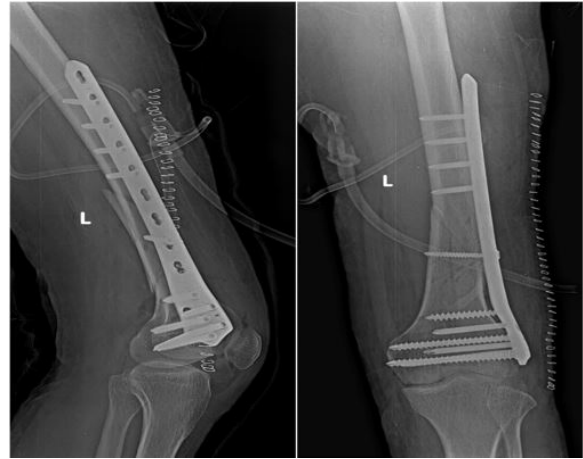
X-ray of the patient after the operation
